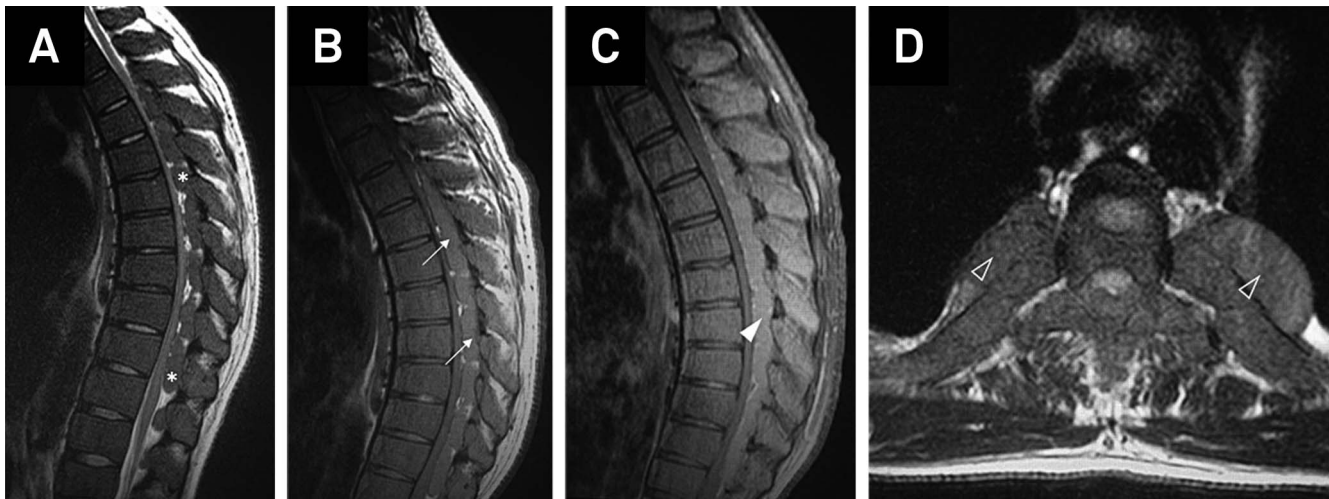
Non-contrast-enhanced sagittal MRI of the spine at thoracic level disclosing multiple solid masses in the paravertebral spine with intermediate signal on T2-weighted (A; asterisks) and on T1-weighted images (B; arrows). Contrast-enhanced T1-weighted sagittal MRI of the spine showing enhancement of the solid masses described in A and B (C; filled arrowhead). Axial T2-weighted MRI of the spine evinced severe thoracic spinal stenosis and multiple paravertebral masses (D; non-filled arrowhead).
